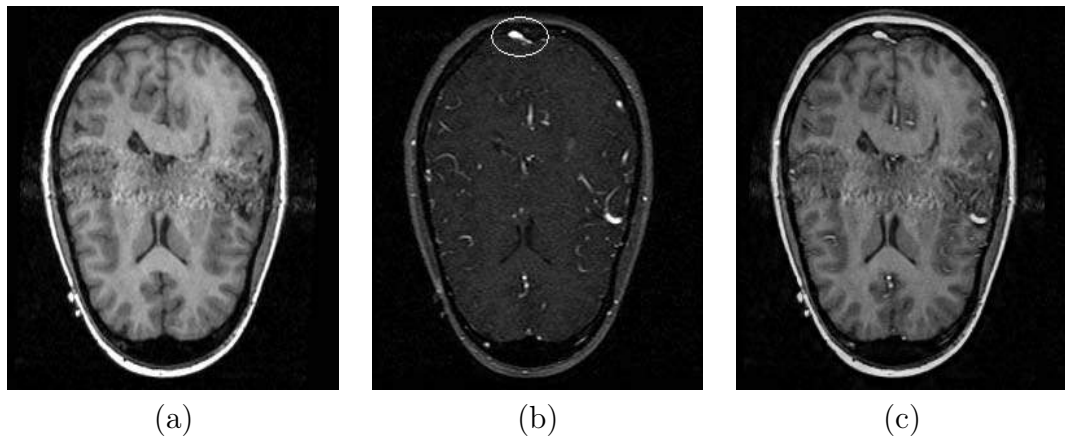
Need of image fusion: (a) Source Image 1: T1-weighted MR; (b) Source Image 2: MR angiography; (c) Fused image.
